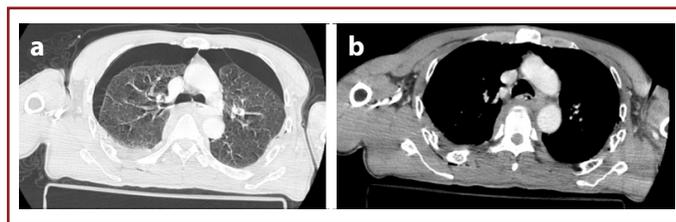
(a) Computed tomography scan of the chest showing. (b) Bilateral multiple rib fractures. Bilateral hemopneumothorax and multiple lung contusions, especially on the right.
